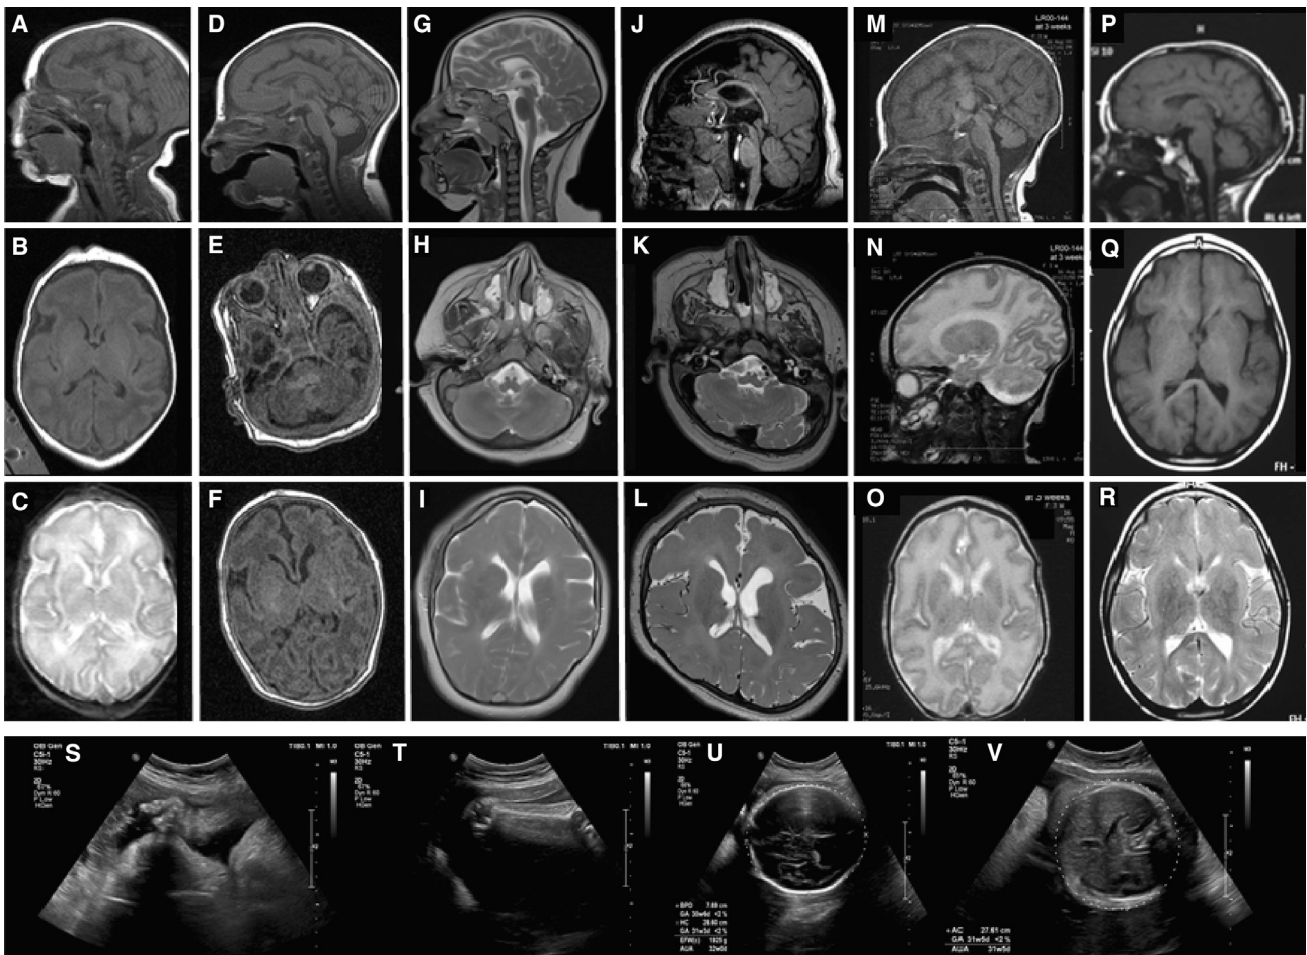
Brain Imaging and Prenatal Ultrasound of Affected Individuals
